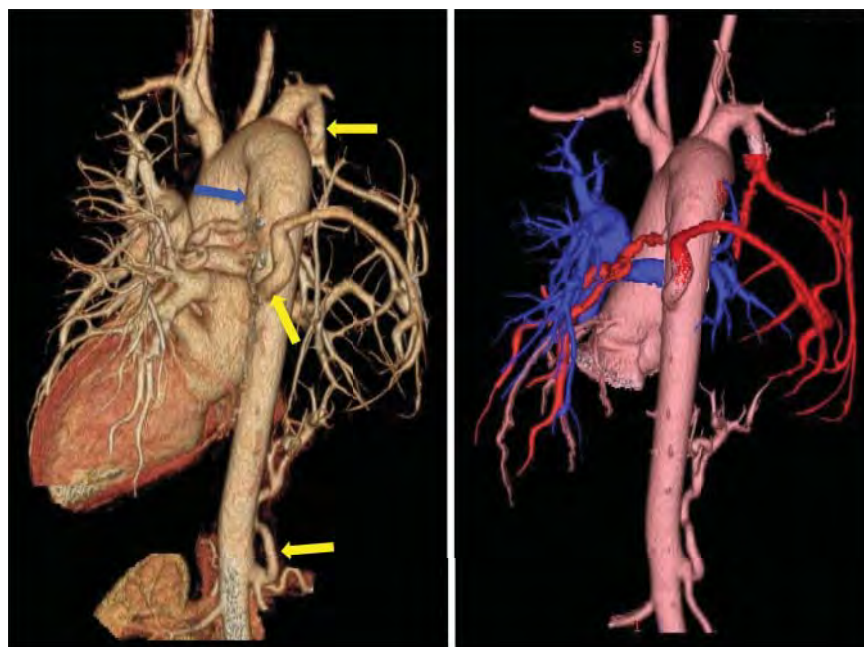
Computed tomography angiography of a patient with pulmonary atresia with ventricular septal defect. Multiple major aortopulmonary collateral arteries (yellow arrows) can be seen. Blue arrow points at the patent ductus arteriosus perfusing the central pulmonary arteries. The color coded image (right panel) highlights native pulmonary arteries (blue), collateral arteries (red), and aorta (pink). One major collateral is arising from the right renal artery.
